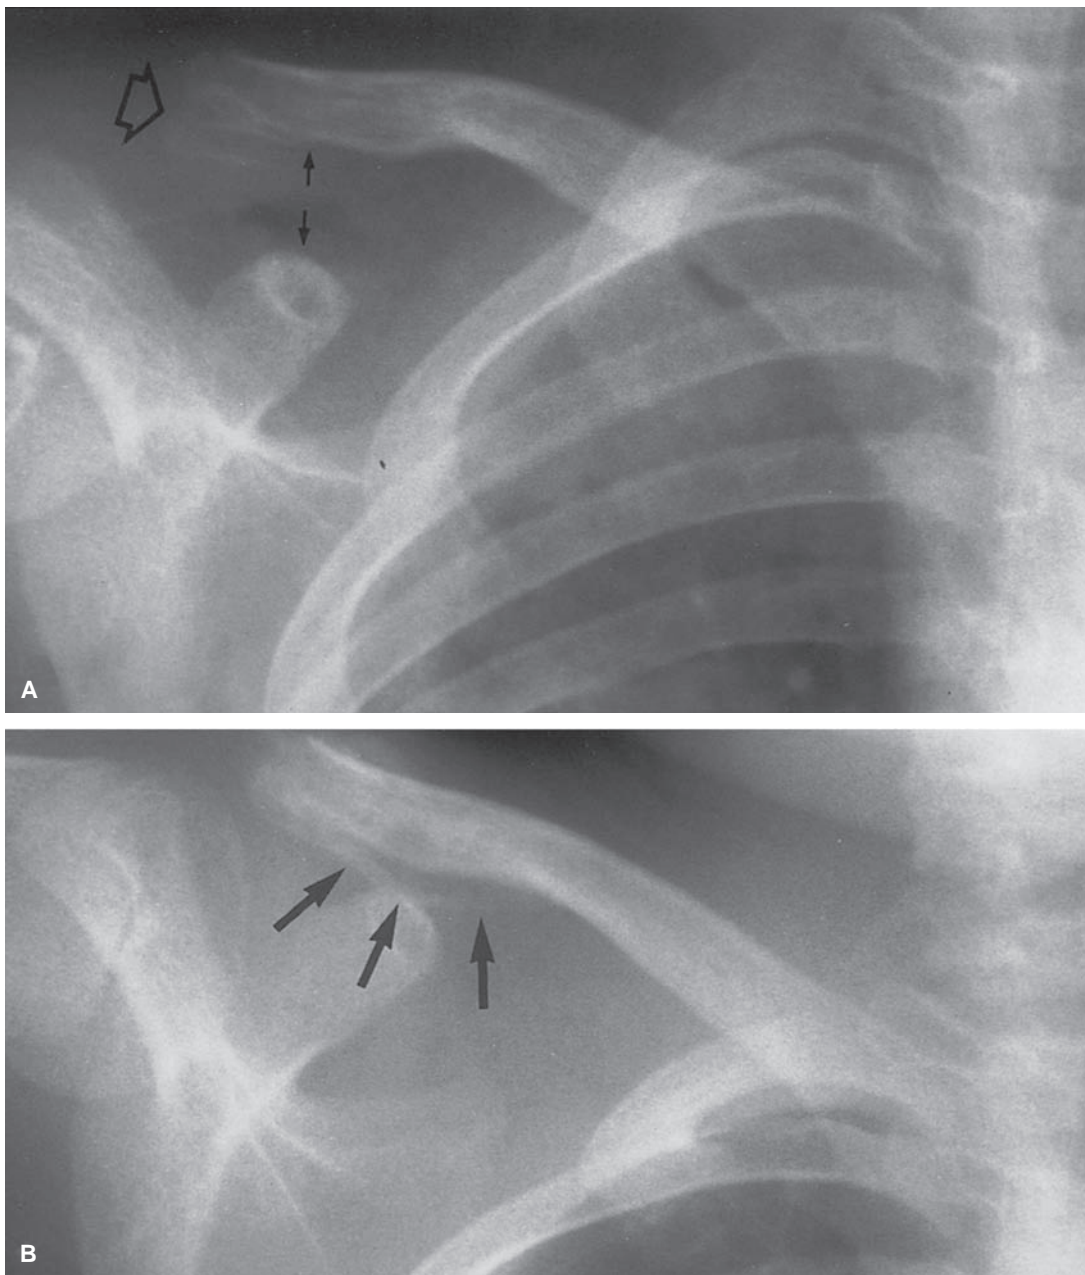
Radiograph of the right clavicle of a 5-year-old child. A: A lateral clavicular fracture (*open arrow*) and widening of the space between the clavicle and the coracoid process (*small arrows*) are evident on the initial film. B: The pattern of new bone formation (*arrows*) seen on the follow-up radiograph demonstrates that the periosteum and the ligaments have remained intact inferiorly.
